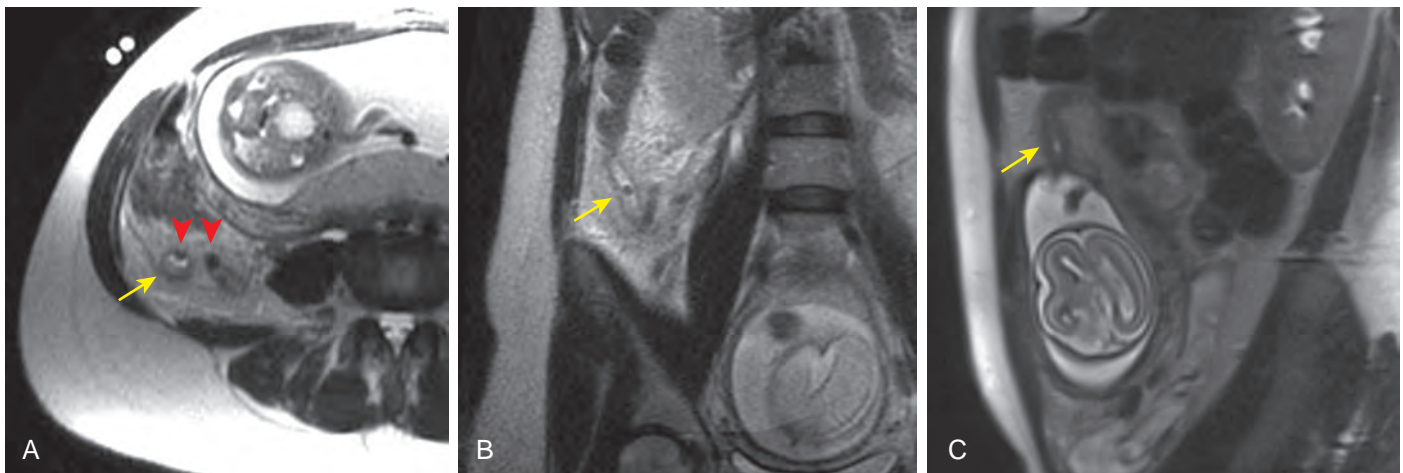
MRI scans of acute appendicitis during pregnancy. A. Axial T2-weighted HASTE imaging shows a dilated, fluid-filled appendix (arrow) surrounded by low signal fat stranding. There are multiple low signal fecaliths within the appendiceal lumen (arrowheads). B. A coronal HASTE image shows the dilated appendix and fecalith (arrow). C. In a second patient, sagittal T2-weighted HASTE imaging shows the appendix, with marked, low-signal wall thickening (arrow).
